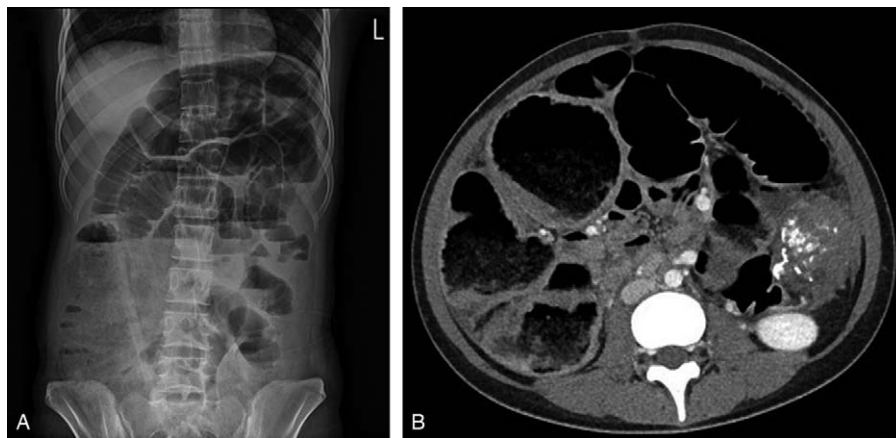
(A) Simple abdominal x-ray (B) abdominal CT. It shows paralytic ileus due to mechanical obstruction, suspicious of adenocarcinoma with peritoneal seeding. CT=computed tomography.
